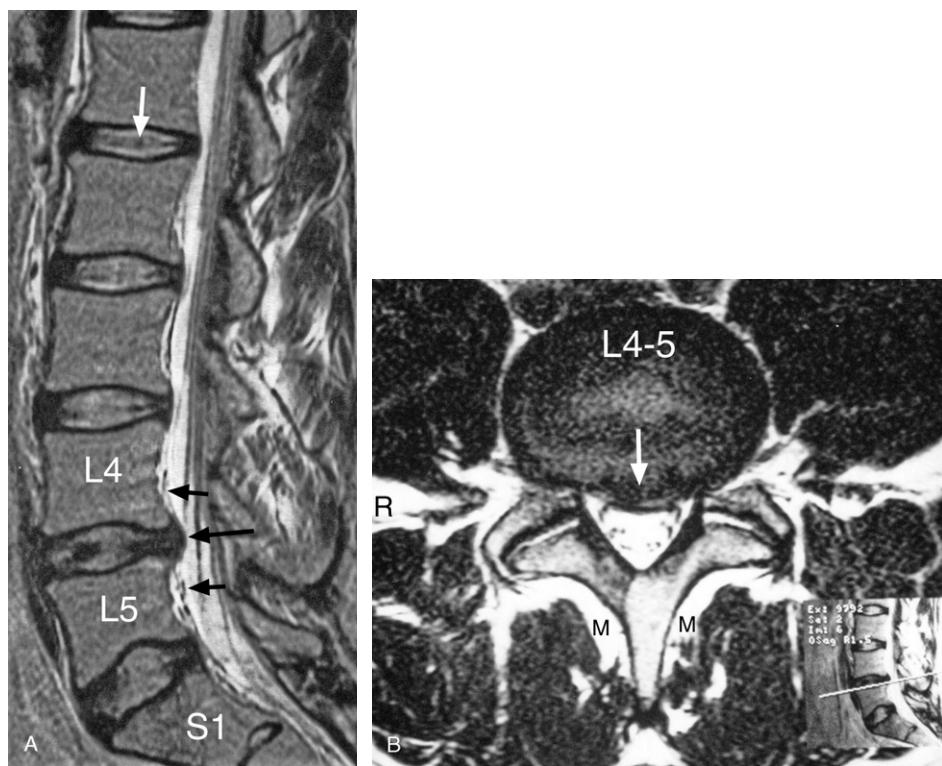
(A) Lumbar spine MRI sagittal T2-weighted image showing reduced signal intensity (blackening) of the L4–5 intervertebral disc, and to lesser extent of the L5–S1 disc, compared to the remaining discs. Also note the prominent disc protrusion (large black arrow) that is pressing upon the pain-sensitive anterior part of the dural tube (small arrows). Signal from the vertebral bodies is essentially normal. The intranuclear cleft (white arrow) is essentially normal in the four discs above the injured L4–5 disc level. (B) Lumbar spine MRI axial T2-weighted image through the L4–5 disc showing the prominent broad-based central disc protrusion (white arrow) compressing the pain sensitive anterior part of the dural tube. In addition, note the fibro-fatty replacement of part of the multifidus muscle (M).
